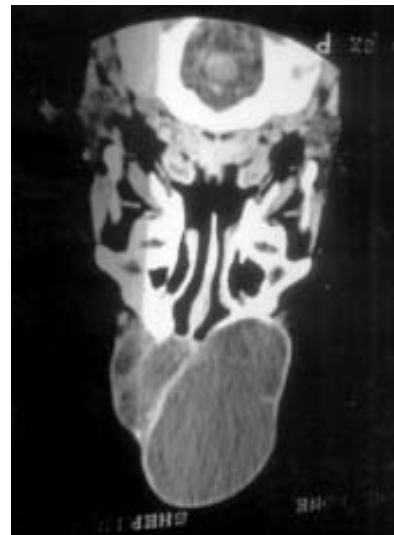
CT scan of the same case.
